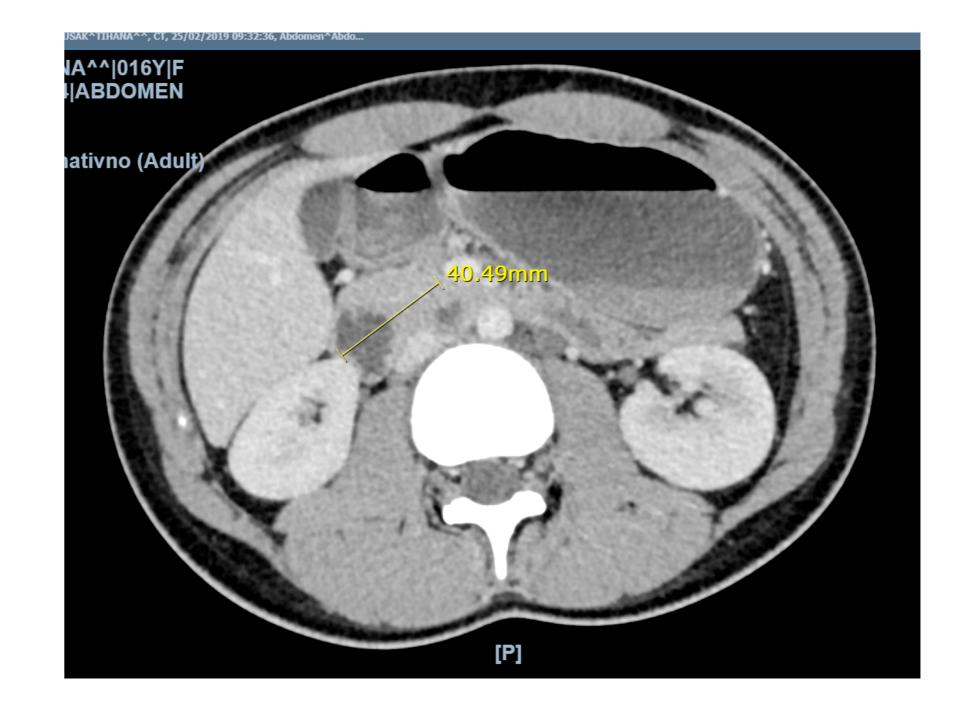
Abdominal CT scan showing tumor in right adrenal gland.
